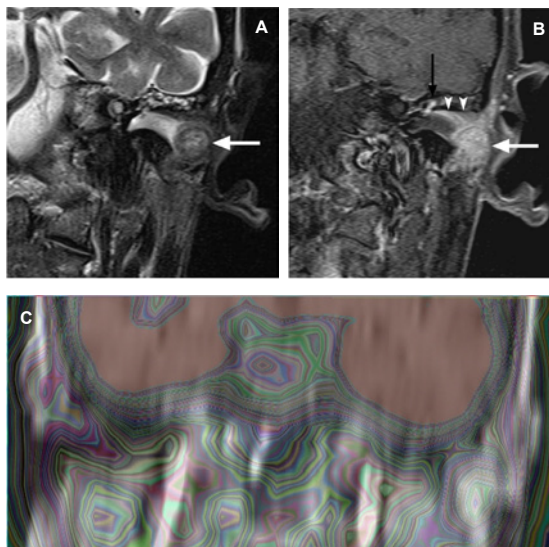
(A) Coronal T2-weighted image through the left internal auditory canal demonstrates a heterogeneous, slightly hyperintense mass filling the lateral aspect of the EAC (white arrow). Postobstructive secretions fill the remainder of the EAC. (B) Coronal contrast enhanced, fat suppressed T1-weighted image demonstrates strong, mostly homogeneous enhancement of the tumor (white arrow). Enhancing tumor also tracks along the roof of the EAC (arrowheads) into the epitympanum (black arrow). (C) Fused PET and gadolinium-enhanced MR sagittal image demonstrating heterogeneity in FDG uptake and signal intensity on MR images.
